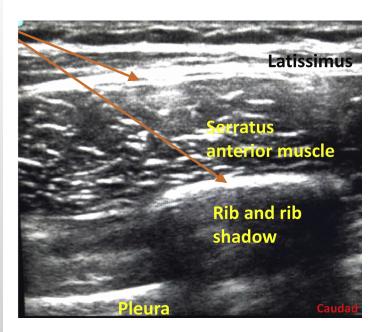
Ultrasound image depicts the serratus anterior plane block. Orange arrows depict needle trajectory for both superficial and deep local anesthetic placement options.
